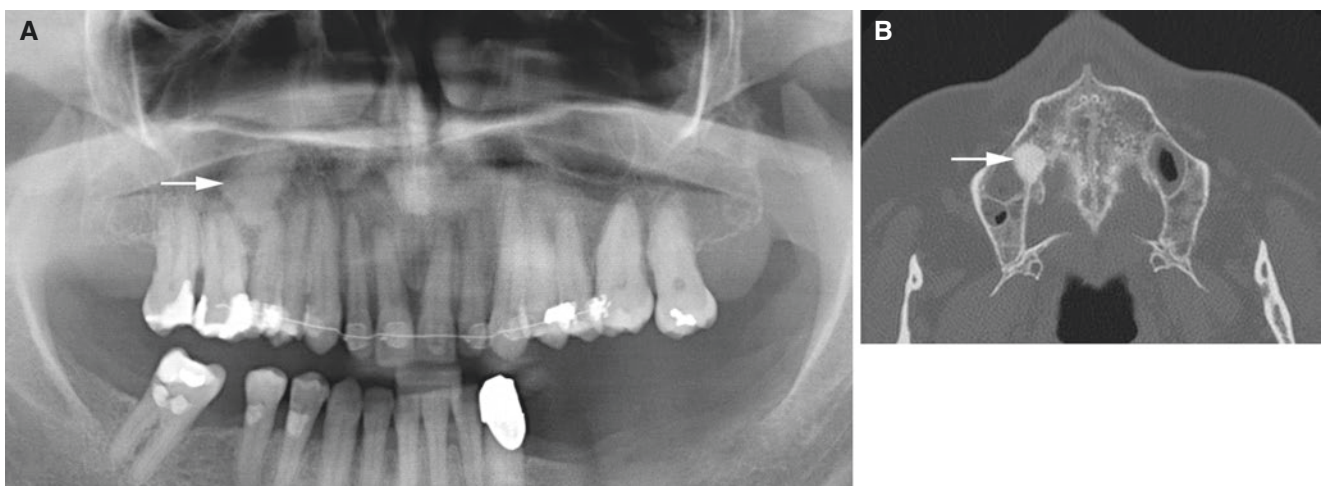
Idiopathic osteosclerosis; 59-year-old male, incidental finding in the right maxilla. (A) Panoramic view and (B) axial CT image show well-defined (sharply delineated) radiopacity without radiolucent peripheral zone (*arrow*)
